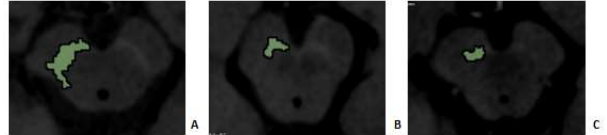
Neuromelanin (NM) area selection on NM sensitive magnetic resonance images of the SN of a healthy control (a), a *de novo* PD patient (b) and a LSPD patient (c).
